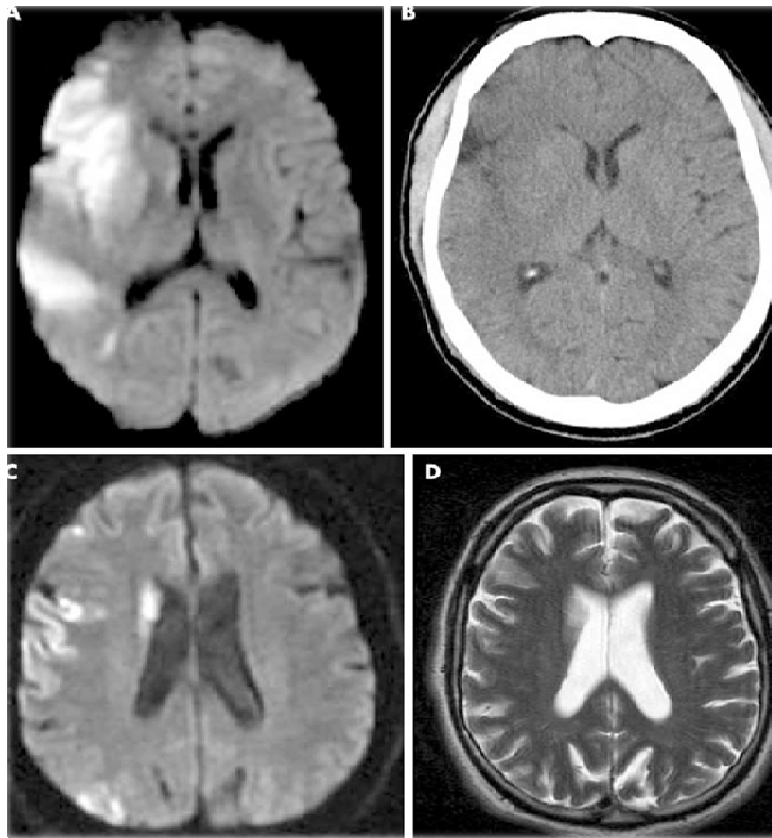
Improved lesion conspicuity of DWI in acute ischaemic stroke. (A) DWI and (B) CT in acute right MCA occlusion. CT shows early ischaemic changes (sulcal effacement, loss of greywhite differentiation, compression of lateral ventricle, loss of posterior lentiform nucleus definition, anterior insular ribbon loss). (C) DWI and (D) conventional T2 weighted MRI in multifocal (post-thrombolytic treatment) right MCA infarction.
